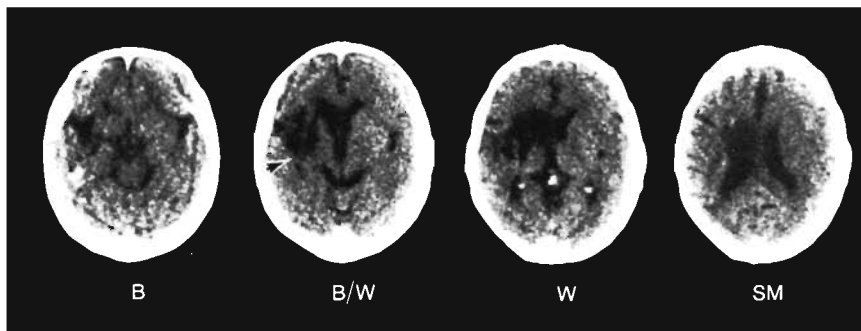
Computed tomographic scan (case 6) done at 31 months after stroke. Subcortical lesion site is capsular/putaminal with posterior lesion extension (arrow is at temporal isthmus).
